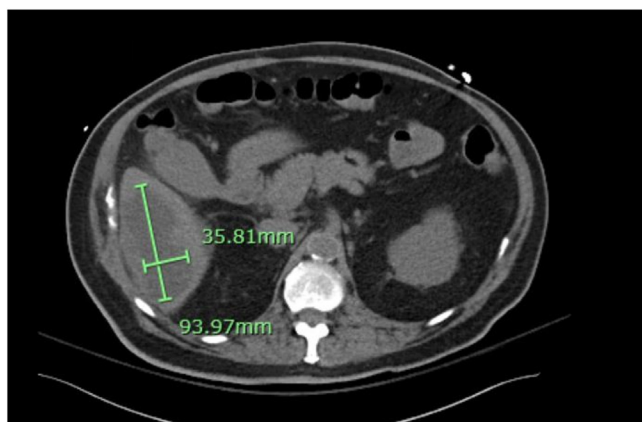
Contrast CT of the abdomen showing a liver collection in the left lobe with dimensions noted.
